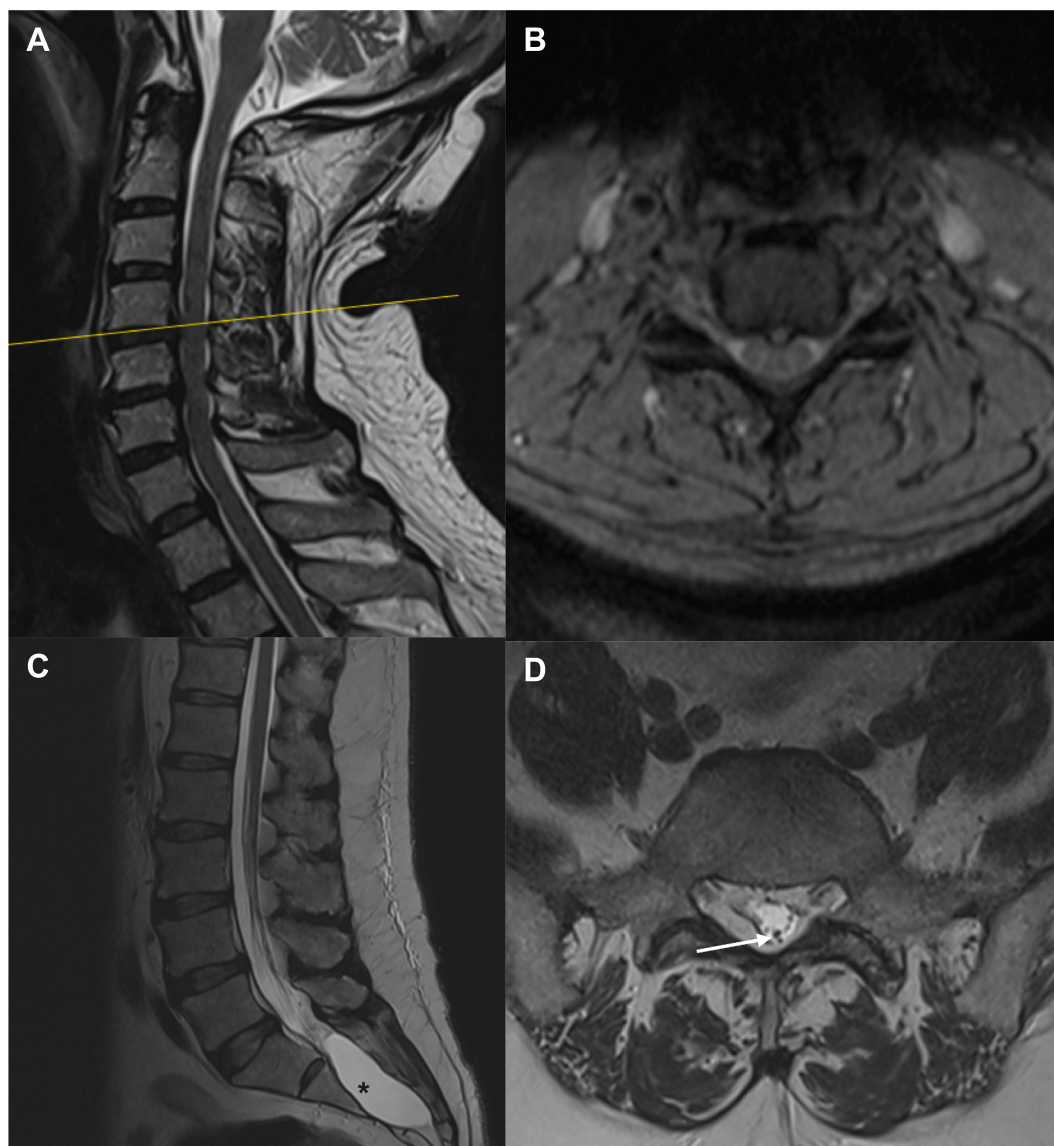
Representative Case #2. 60 M with thickened filum and sacral lipoma presents with cervical spine degeneration without myelopathy, urge incontinence and progressive radicular leg pain. Preoperative magnetic resonance imaging demonstrates cervical stenosis most notable at C4-C5 and C5-C6 (A,B) as well as lumbosacral filum thickening (arrow) and sacral arachnoid cyst (asterisk), suggestive of spina bifida occulta (C,D).
